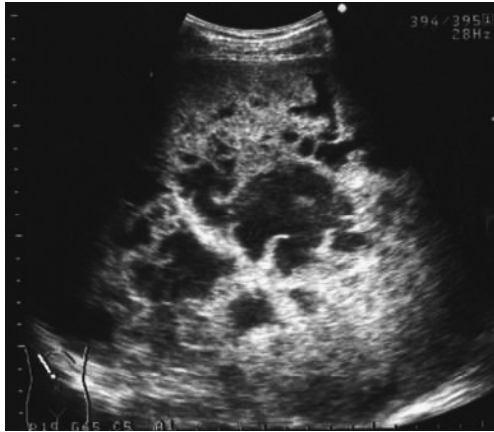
Ultrasonography revealed a large cystic mass containing many hyperechoic structures and occupying nearly the entire right hepatic lobe.
